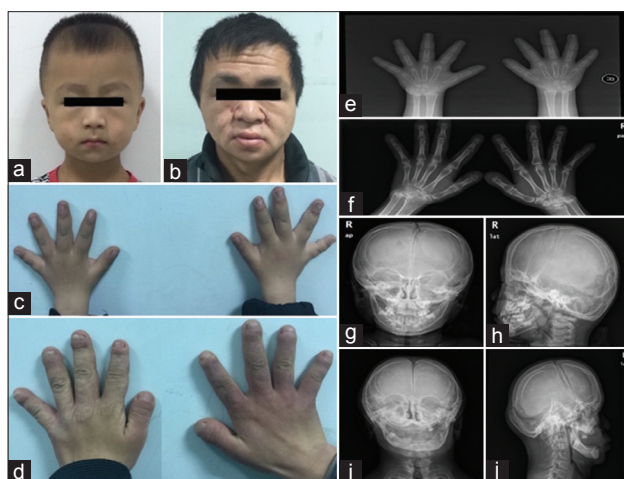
Photographs of the faces in patient 1 (son, a) and patient 2 (father, b) show large anterior fontanelle, bushy eyebrows, synophrys, shallow orbit, mild proptosis, hypertelorism, flat nasal bridge, thin upper lip, micrognathia, downslanted palpebral fissures, and short neck. Photographs of the hands in patient 1 (c) and patient 2 (d) show that most of fingers are short and thick (predominately father's hands). (e and f) Anteroposterior radiographs of the patients' hands show osteoporosis in both father and son, and obvious acroosteolysis in all father's fingers. (g-i) Skull radiographs show that the son had wormian bones in the lambdoidal and coronal sutures (g and h), and the father had wormian bones in the sagittal, coronal, and lambdoidal sutures as well as severe dentition abnormality (i and j).
